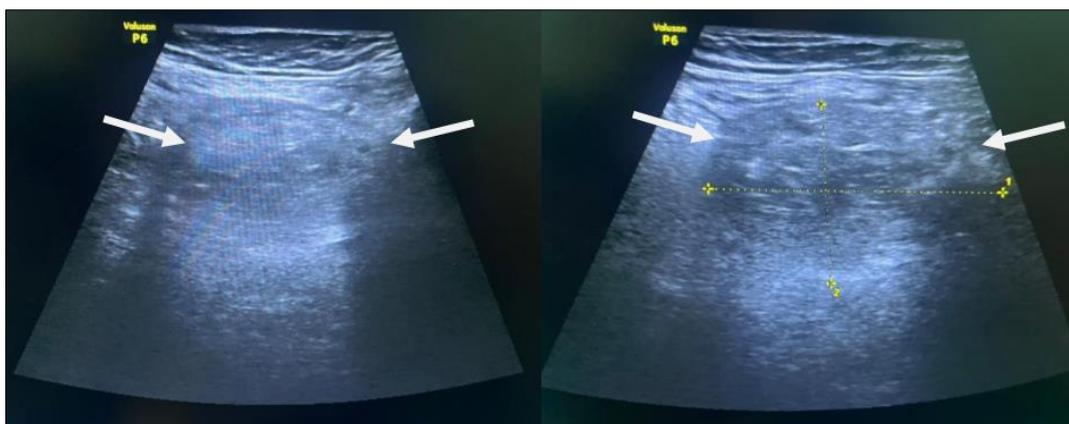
An abdominal ultrasound showing an avascular hyperechoic non-compressible, oval mass located in the right iliac fossa (white arrows), just behind the antero-lateral abdominal wall.
